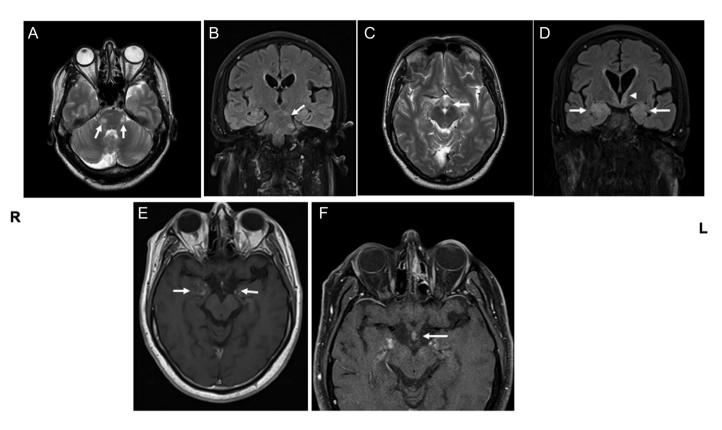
Cranial MRI examination. Nodular hyperintensity is observed in T2- and FLAIR-weighted sections of the Pons (A,B) in the pituitary gland and hyperintensity in T2- and FLAIR-weighted sections around the third ventricle (C, D). Hyperintense lesions are observed in the T2 and FLAIR-weighted sections in the medial of both temporal lobes (D). In contrast-weighted T1-weighted sections, nodular contrast is noted in both hemispheres in the medial temporal lobe (E) Slight contrasting is noted in the optic chiasm (F). MRI, magnetic resonance imaging.
